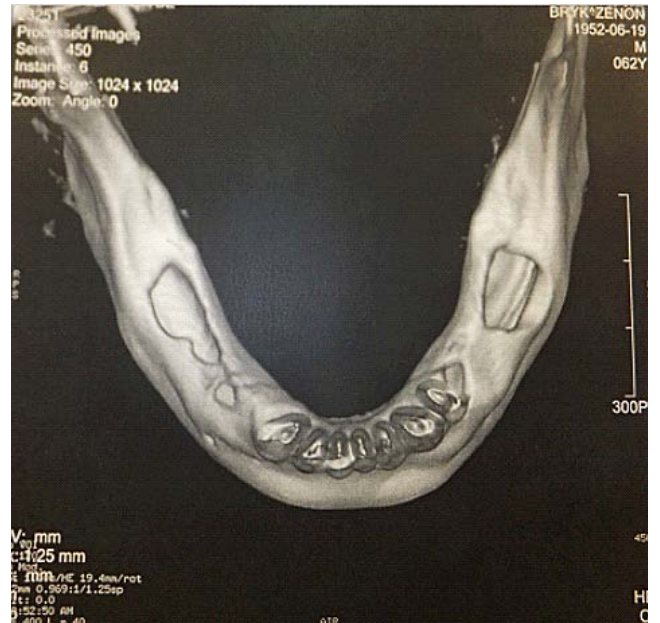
3D CT of the mandible, visible two osteolytic defects with destruction of the mandibular compact bone lamella
